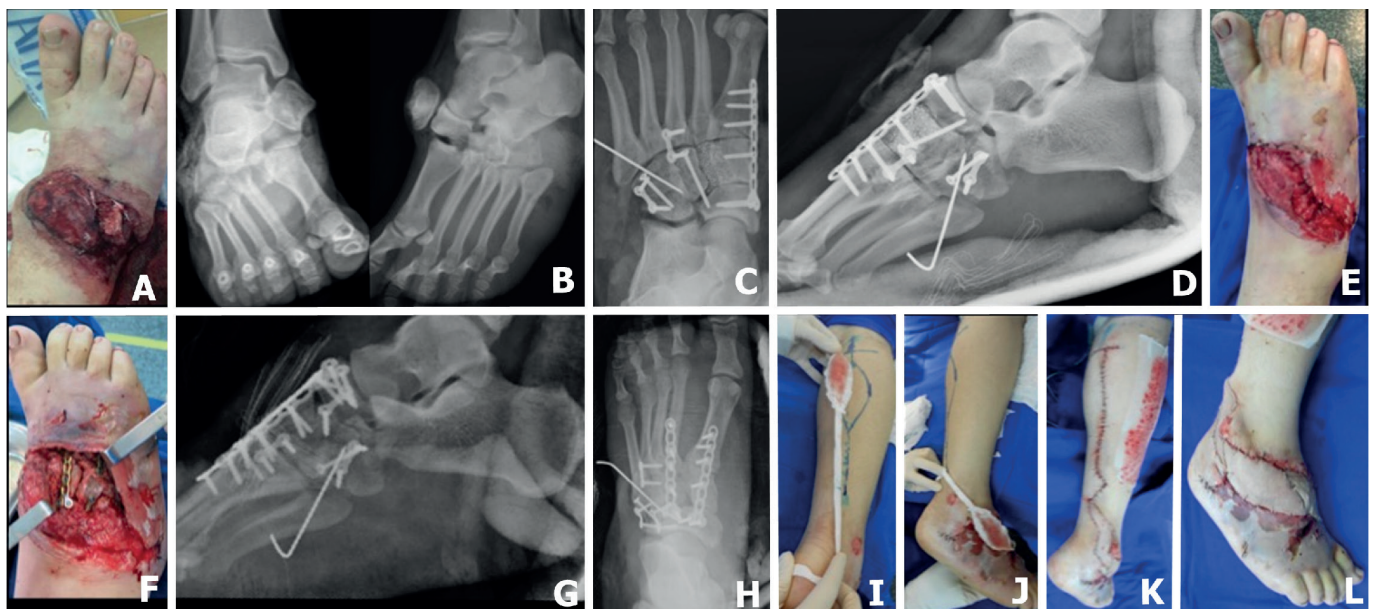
Example of foot reconstruction in complex injuries. 4A. Initial clinical image of the soft tissue injury, 4B. Initial AP radiograph of the ankle and oblique x-ray of the foot, showing tarsometatarsal dislocation-fracture with extrusion of the intermediate cuneiform, 4C. Anteroposterior radiograph after debridement, stabilization of the first, third and fifth radial bones, disimpaction of the cuboid and bone fragment interposition using an antibiotic-impregnated cement spacer in the intermediate cuneiform topography, 4D. Lateral radiograph after debridement, stabilization and bone fragment interposition using an antibiotic-impregnated cement spacer in the intermediate cuneiform topography, 4E. Immediate postoperative clinical presentation following debridement, stabilization and approximation of soft tissues for application of negative pressure dressing, 4F. Intraoperative clinical presentation - 72 hours after the first procedure - filling of bone fragment with autologous bone graft (iliac crest) and definitive fixation of the second radial bone, 4G. Lateral radiograph after definitive treatment 4H. Anteroposterior radiograph after definitive treatment, 4I. Planning of sural rotation flap posterior view, 4J. Planning of rotation flap lateral view, 4K. Final clinical presentation of skin coverage with rotation flap posterior view, 4L. Final clinical presentation of skin coverage with rotation flap lateral view.
